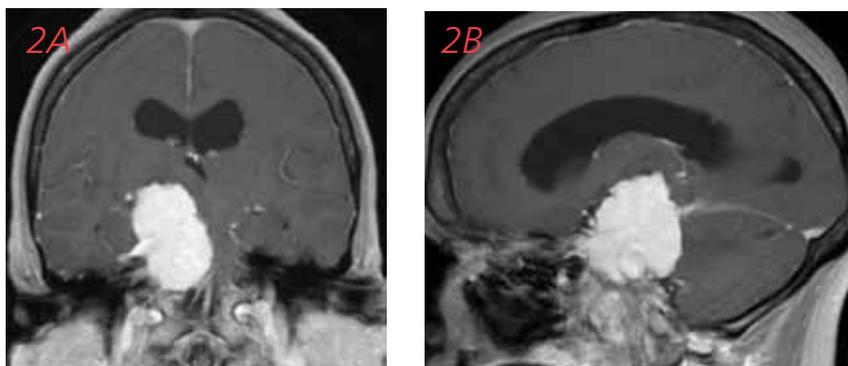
Large petroclival meningioma in coronal (A) and sagittal (B) views. The tumor enhances brightly on post-contrast T1 MR imaging and involves both the middle and posterior cranial fossae.
